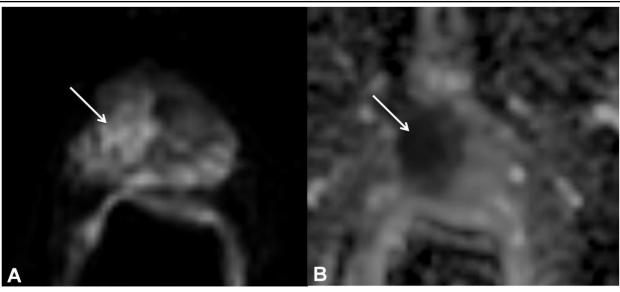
(A-DWI, B-ADC) DWI PIRADS score 5 Focal area/mass of hyper SI on the high b-value image with reduced ADC.
